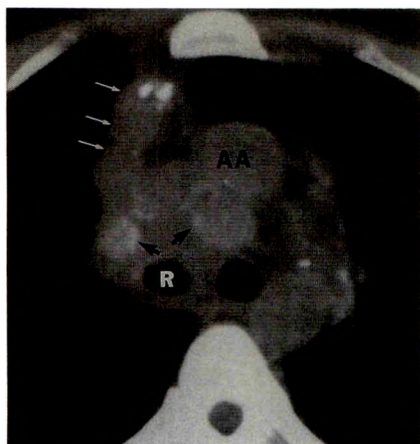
Bronchogenic carcinoma. CT scan shows areas of amorphous calcification (black arrows) within central right upper lobe mass and mediastinal lymphadenopathy. Scans through liver showed multiple, partially calcified liver metastases. Subsequent bronchoscopic biopsy of right main bronchus disclosed epidermoid carcinoma. Right upper lobe atelectasis (white arrows). AA = ascending aorta, R = right main bronchus.
